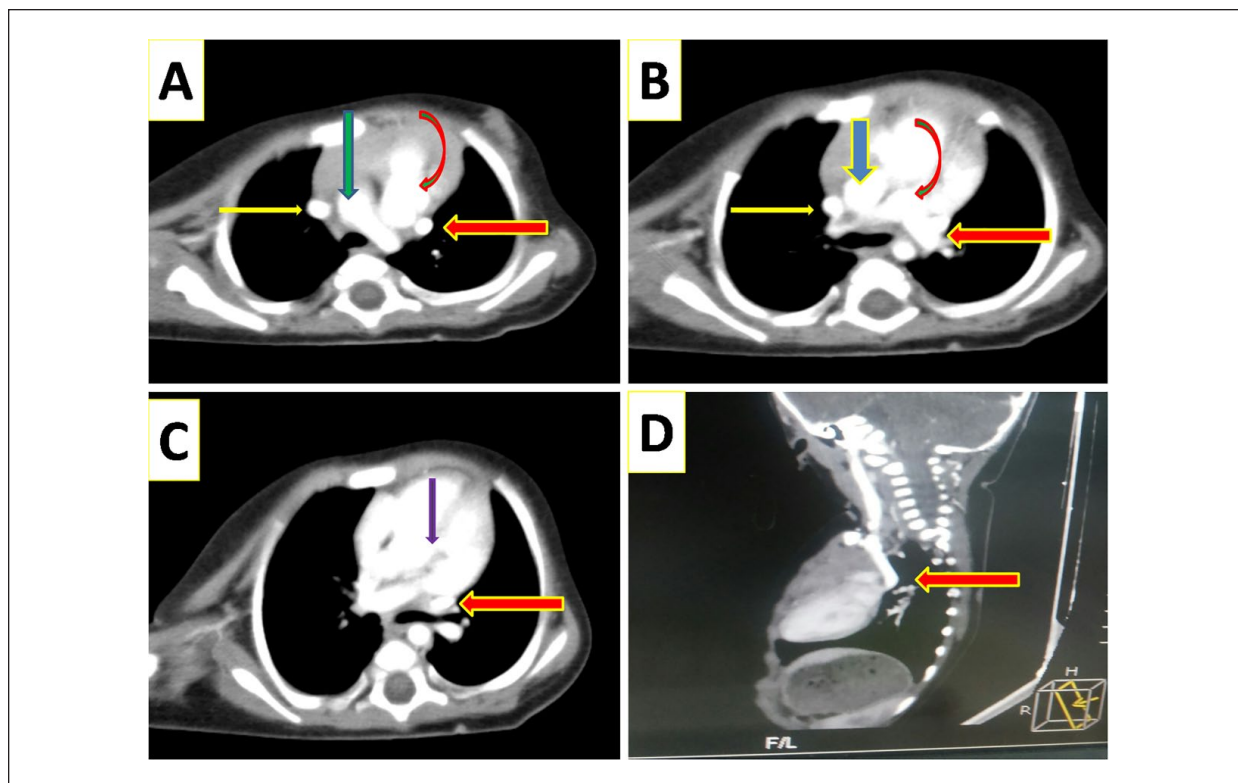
Contrast enhanced computed tomographic images: (A) At the level of arch of aorta. Yellow straight arrow on right-showing right SVC, Green arrow showing arch of aorta, Red curvilinear arrow showing-pulmonary trunk and Red arrow on left shows Left SVC. (B) Yellow arrow on right shows RSVC, Blue arrow shows right atria, Curvilinear red arrow showing pulmonary trunk and Red arrow on left shows LSVC. (C) Red arrow -Left SVC draining into the coronary sinus. (D) Oblique section showing whole course of left SVC draining into coronary sinus.
